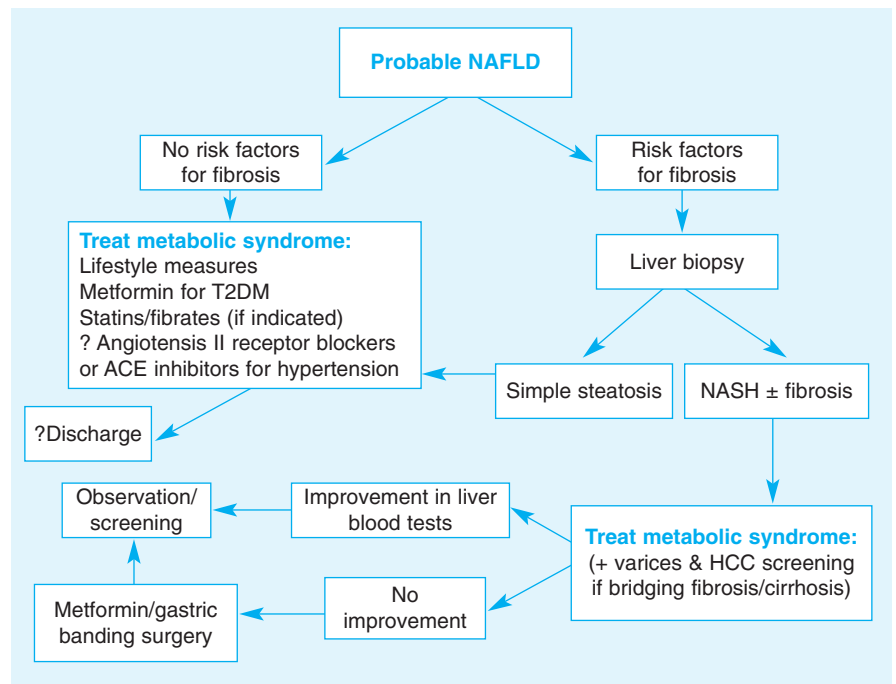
Management strategy for patients presenting with suspected non-alcoholic fatty liver disease (NAFLD). They are assumed to have had alternative causes of abnormal liver blood tests excluded by history (for alcohol excess and hepatotoxic drugs) and serology (for autoimmune disease and viral hepatitis), with steatosis detected on abdominal ultrasound (ACE = angiotensin converting enzyme, HCC = hepatocellular carcinoma, NASH = non-alcoholic steatohepatitis, T2DM = type 2 diabetes mellitus).
